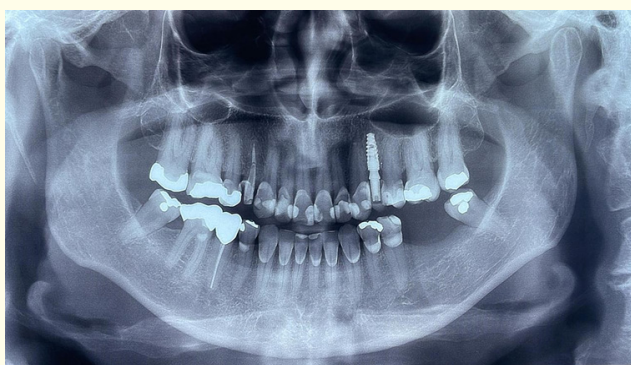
4th postoperative month Panoramic Radiograph, showing adequate implant-bone contact.
